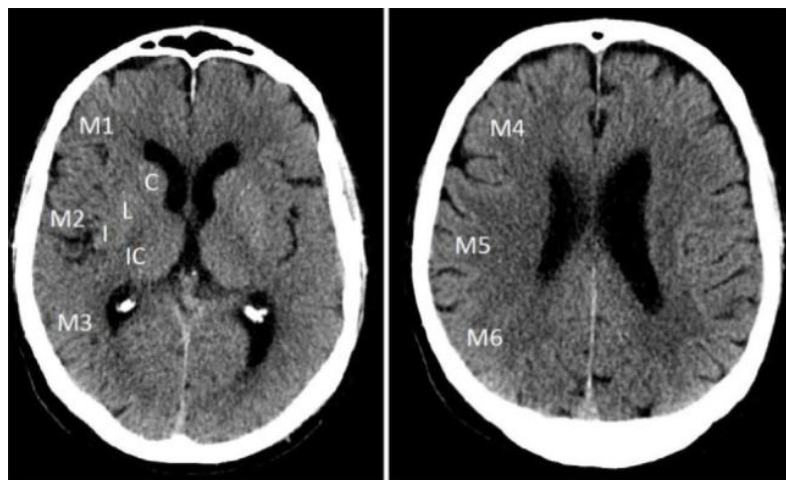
Template for Alberta Stroke Program Early Computed Tomography Score on non-contrast CT includes 10 regions spread across MCA territory at ganglionic and supraganglionic levels (Schröder & Thomalla, 2017).
